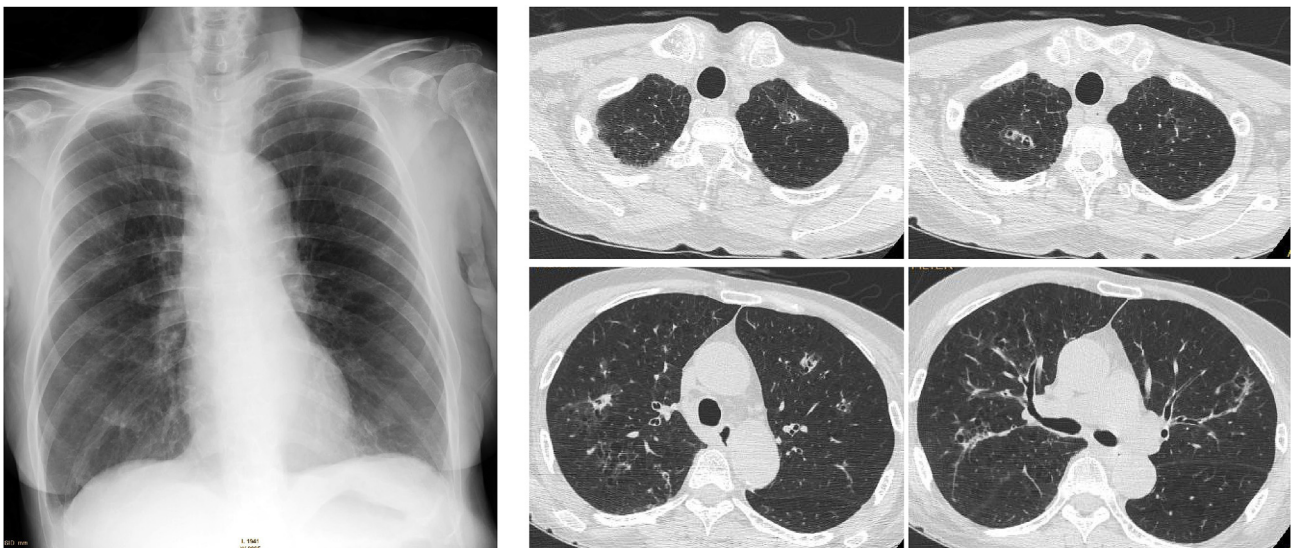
a: A chest X-ray showed infiltration in middle and lower lesions of both lungs on admission. b: Chest CT images showed low attenuation area (LAA) throughout in upper lobe and small thin-walled cavities surrounded by GGO on admission.
